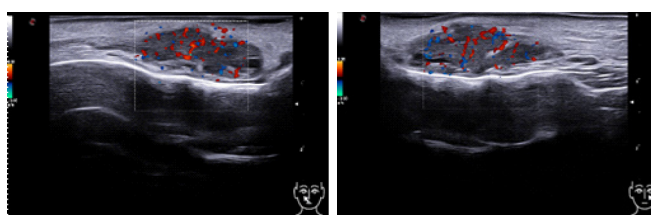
Echograms of soft tissues of the subglacial areas in Color Doppler, right (3) and left (4) sides.
